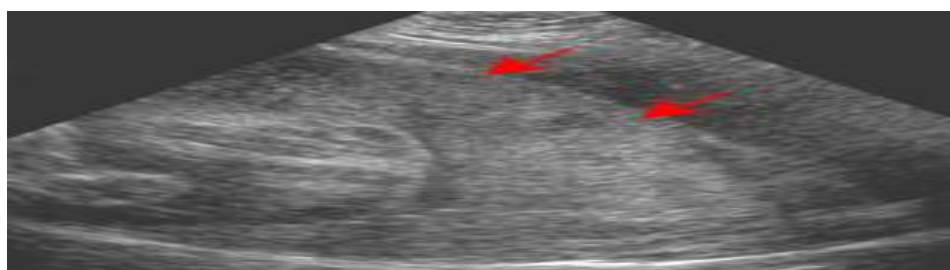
Ultrasonography of placenta accreta<sup>52</sup>.
